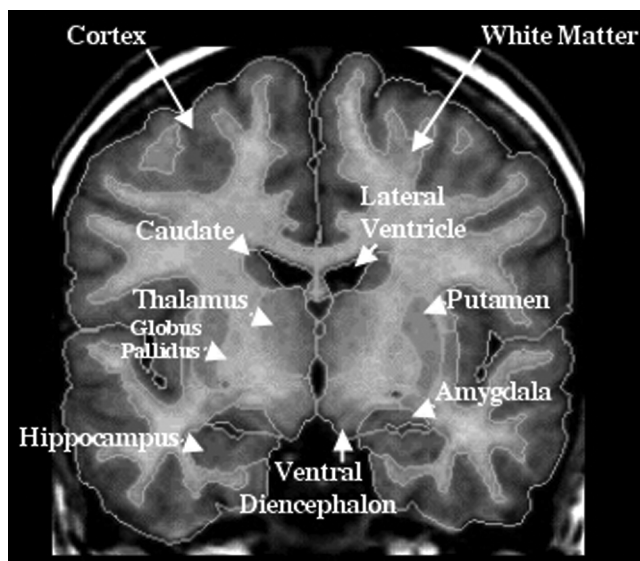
T₁-weighted magnetic resonance imaging coronal slice showing subcortical regions of interest.
